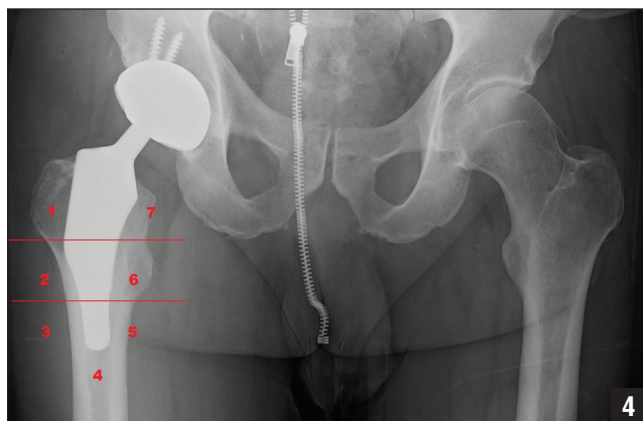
Anteroposterior pelvis radiograph of a 69-year-old man at 6-year follow-up showing Gruen zone assessment of a custom short-stem femoral implant.
